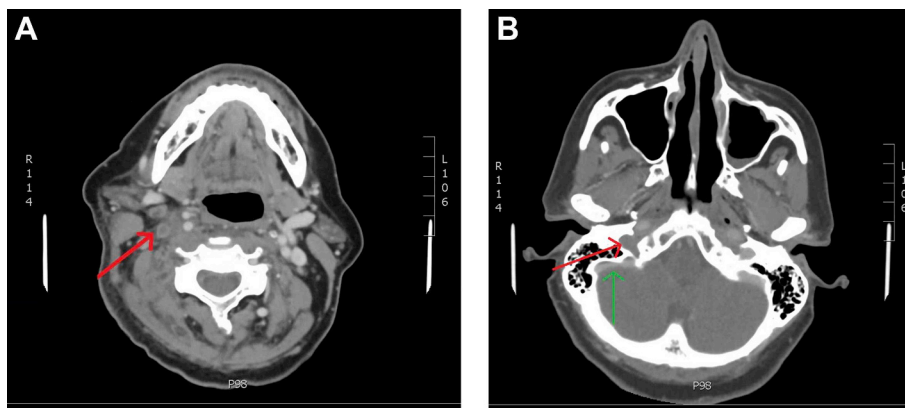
Sagittal CT scan A. Filling defect of right internal jugular vein (red arrow). B. Filling defect extending to right transverse (red arrow) and sigmoid sinuses (green arrows). (For interpretation of the references to color in this figure legend, the reader is referred to the Web version of this article.)
